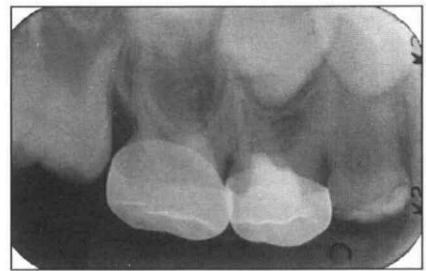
Root canal calcification following treatment with ferric sulfate. Radiograph exposed of first primary molar at 3-month postoperative period (2a, left). Radiograph at 12-month postoperative period with calcification of the mesiobuccal root canal (2b).
